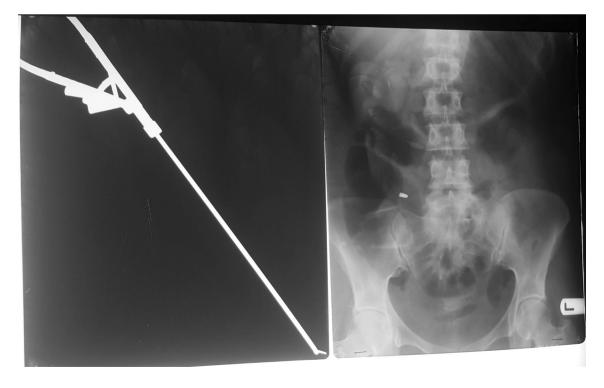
Abdominal X-ray showing the tip of the broken needle holder in the abdominal cavity
